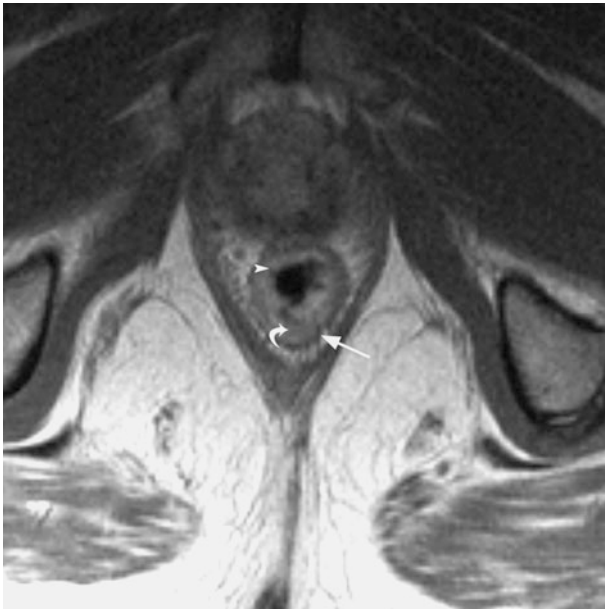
The normal rectal wall as seen on axial T2-weighted images signal surrounding the low signal of the muscularis propria (Fig. 6).
